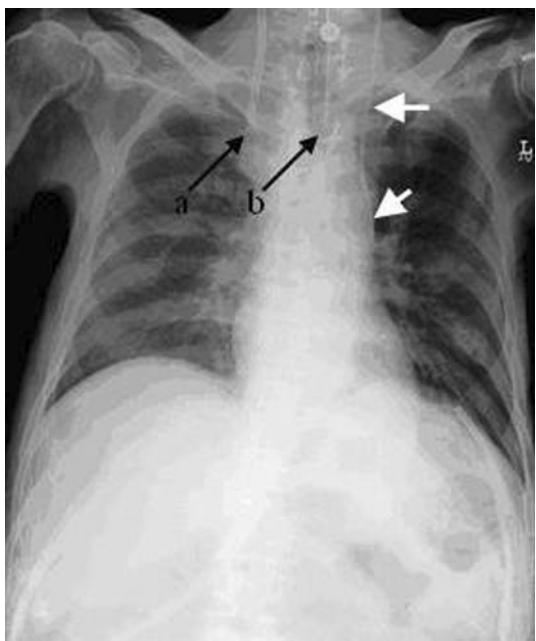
Chest roentgenogram shows the 8 Fr. CVC (white arrows) descending lateral to the left mediastinal margin. The black arrows indicate the 9 Fr. trauma catheter (a) and tracheal tube (b)
